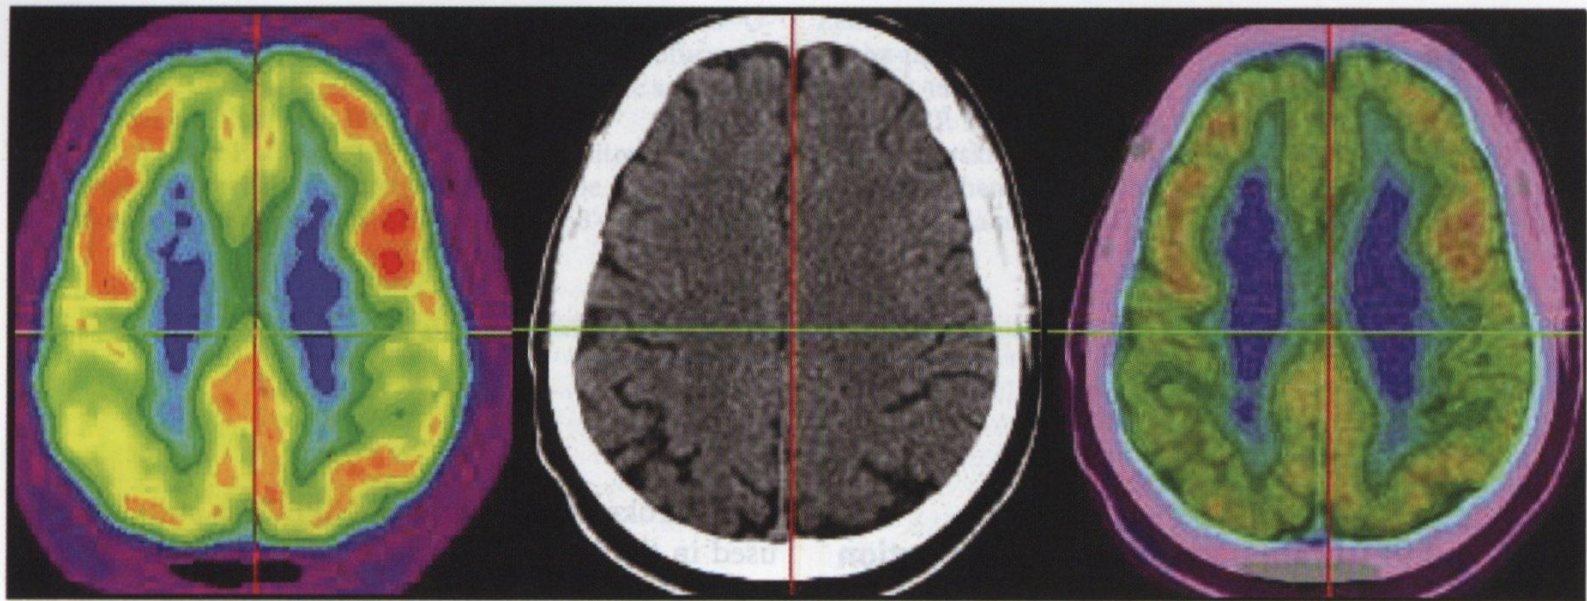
The value of PET/CT in the evaluation of Alzheimer's disease – transverse plane FDG-PET (*left*), CT (*middle*) and fused PET/CT (*right*) images. Study reveals evidence of bilateral posterior parietal hypometabolism without evidence of significant cortical atrophy on CT
